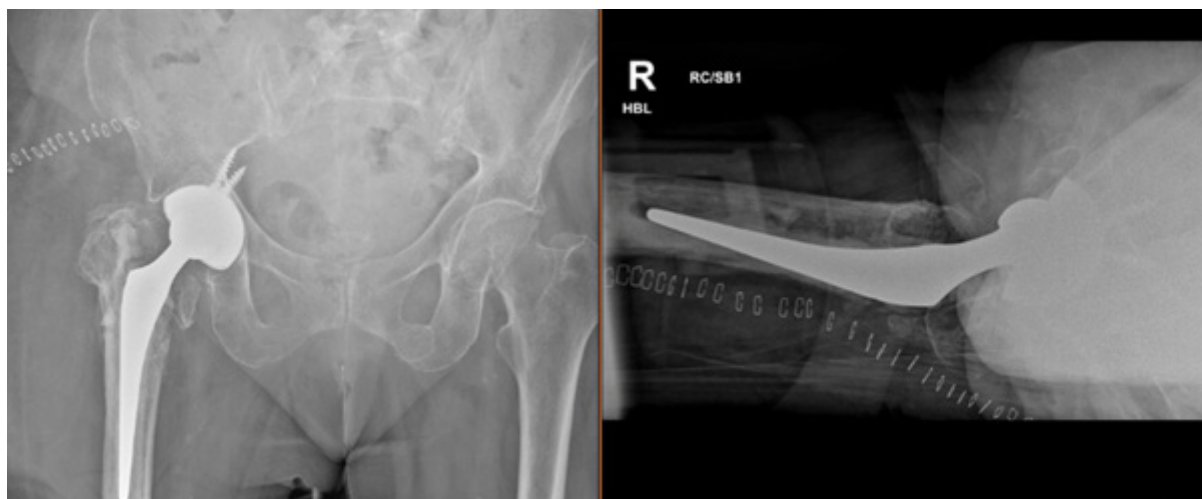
AP and lateral radiographs following revision dual mobility total hip replacement
